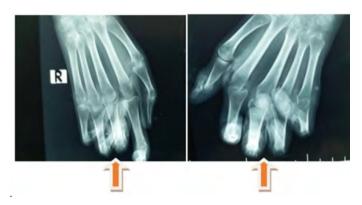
X-ray taken 15 months later, when gout was discovered. Joint destruction was more advanced on the proximal interphalangeal joints with associated subluxation.
